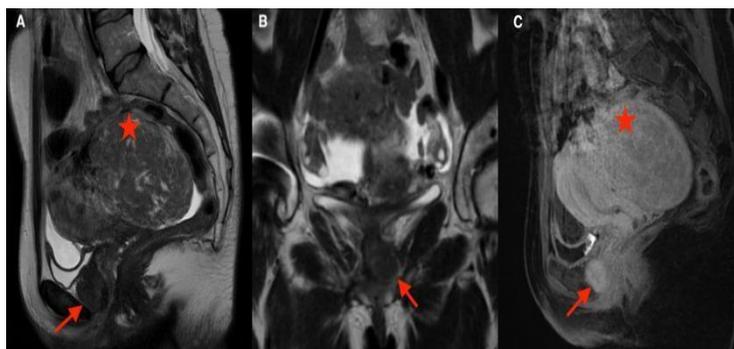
T2-weighted sagittal (A) and coronal (B) images reveal a well-defined round lesion (red arrow) located anteriorly to the urethra, characterized by low signal intensity; on the posterior aspect of the uterus, a voluminous subserosal myoma (red star) shows a similar signal intensity to the urethral leiomyoma, but with an inhomogeneous appearance due to the presence of hyperintense components in the context as for cystic degeneration. T1-weighted sagittal image after gadolinium administration in the late phase (C) shows the same uniform contrast enhancement of the paraurethral leiomyoma and uterine myoma.
